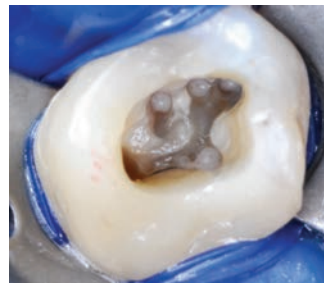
Final access cavity preparation after the walls were smoothed with a Start-X No. 1 ultrasonic tip and the mesial canal orifices were enlarged with an X-Gates bur
